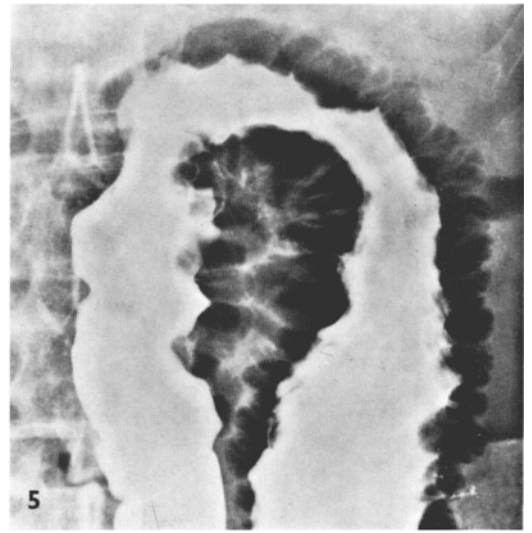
A *Pneumatosis cystoides coli*. A plain film of the abdomen reveals a large lobulated gas shadow in the right upper quadrant. The gas involves the mesentery and outlines the mesenteric blood vessels. B Barium enema examination reveals the presence of gas cysts in the hepatic flexure and right side of the colon
